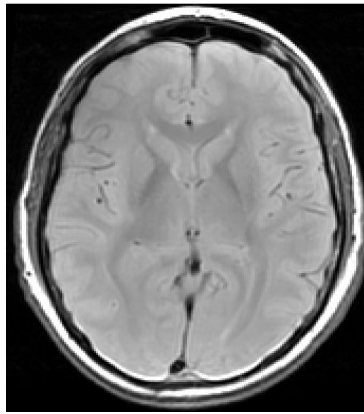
A PD-weighted axial MR image of the brain
